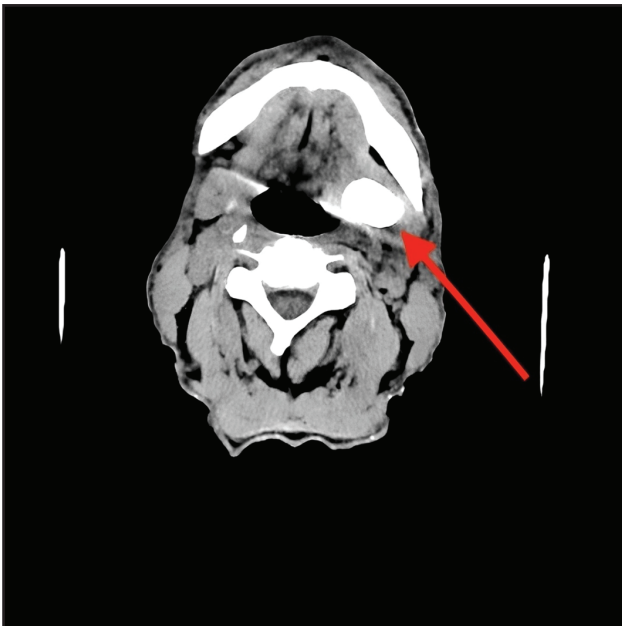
Axial CT scan slice revealing the cylindrical calcified lesion located in the left tonsil with extent to the left submandibular region.
